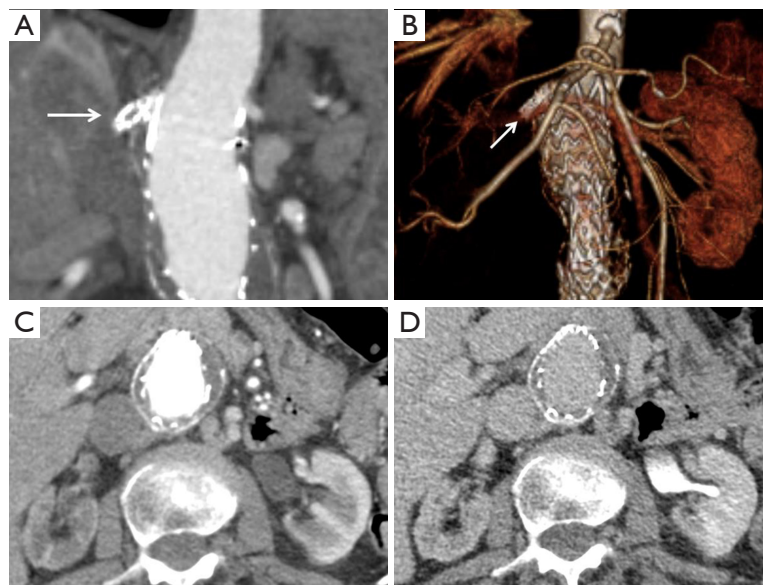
A 75-year-old woman with occlusion of the right renal artery stent and renal infarction. (A) Coronal CT angiogram demonstrates no contrast opacification in the right renal artery stent (arrow); (B) coronal volume rendered CT angiogram shows non-visualized right renal artery and right kidney at distal to renal artery stent (arrow); (C) axial CT angiogram show delayed corticomedullary phase of the right kidney as compared with the left kidney and mild atrophy of the right kidney; (D) axial delayed contrast-enhanced CT shows delayed excretory function of the right kidney.
